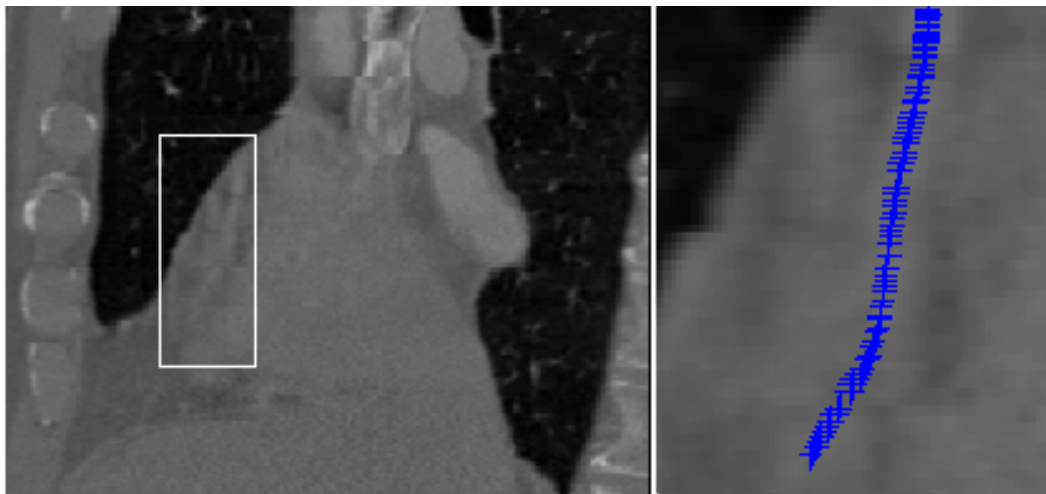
CTA image with stair-step artefacts and its extracted coronary artery centreline. Left: CTA slice with the rectangle marking the region of interest. Right: extracted coronary centreline from the region highlighted by the white box in the CTA image.
